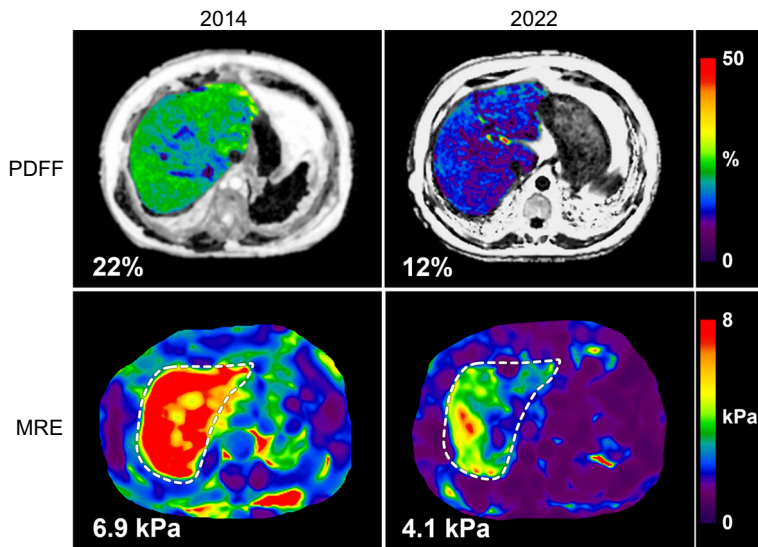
Hepatic improvement in a 63-year-old man, diagnosed in 2014 with type 2 diabetes, obesity and hyperlipidemia, after antidiabetic therapy and successful implementation of dietary and lifestyle changes. Improvement documented by MRI for steatosis (PDFF row) and fibrosis (MRE row). Images courtesy of Dr. Richard Ehman and Dr. Meng Yin, Mayo Clinic, Rochester, MN, USA. MRE, magnetic resonance elastography; PDFF, proton-density fat fraction.
